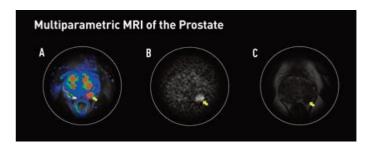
Image description: "Multiparametric MRI uses a dynamic contrast enhancement colour map (A), which shows intravenous contrast, allowing the radiologist to observe the rapidity with which the tissue is enhanced. Here, the image shows a focal area of abnormal perfusion indicated by the red colour. The T2- weighted image (B) can identify tumours by their inherent difference from other areas of tissue. Diffusion-weighted imaging (C) displays the rate of water diffusion in tissues, which can assist in tumour delineation."
